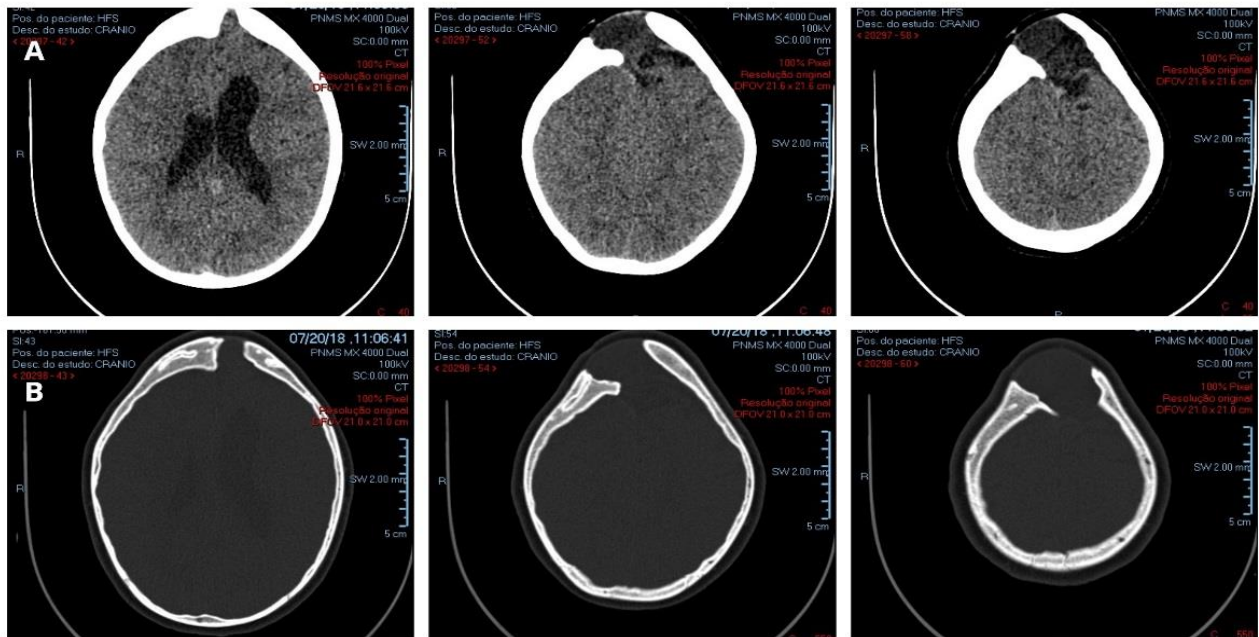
Sequence A of computed tomography of the skull, axial section showing an arachnoid cyst in the frontal lobe protruding
